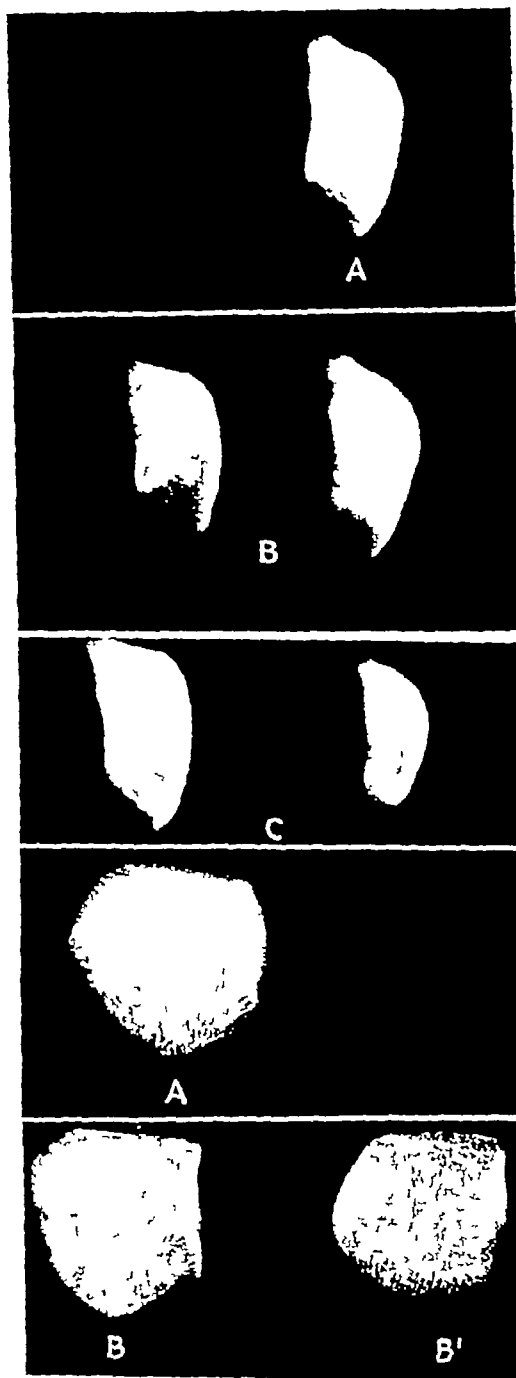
(upper) Roentgenograms of serial sections through a normal macerated patella. A Control. B and C depict sagittal sections through the same bone.
